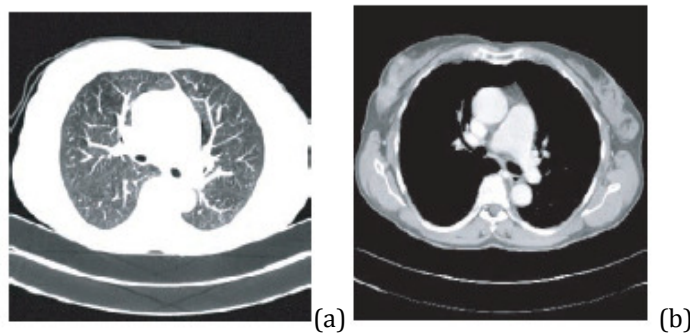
Thoracic CT image: (a) to highlight the lungs details (width 1500 and level -500); (b) to highlight soft tissues (width 350 and level 50)[14].
